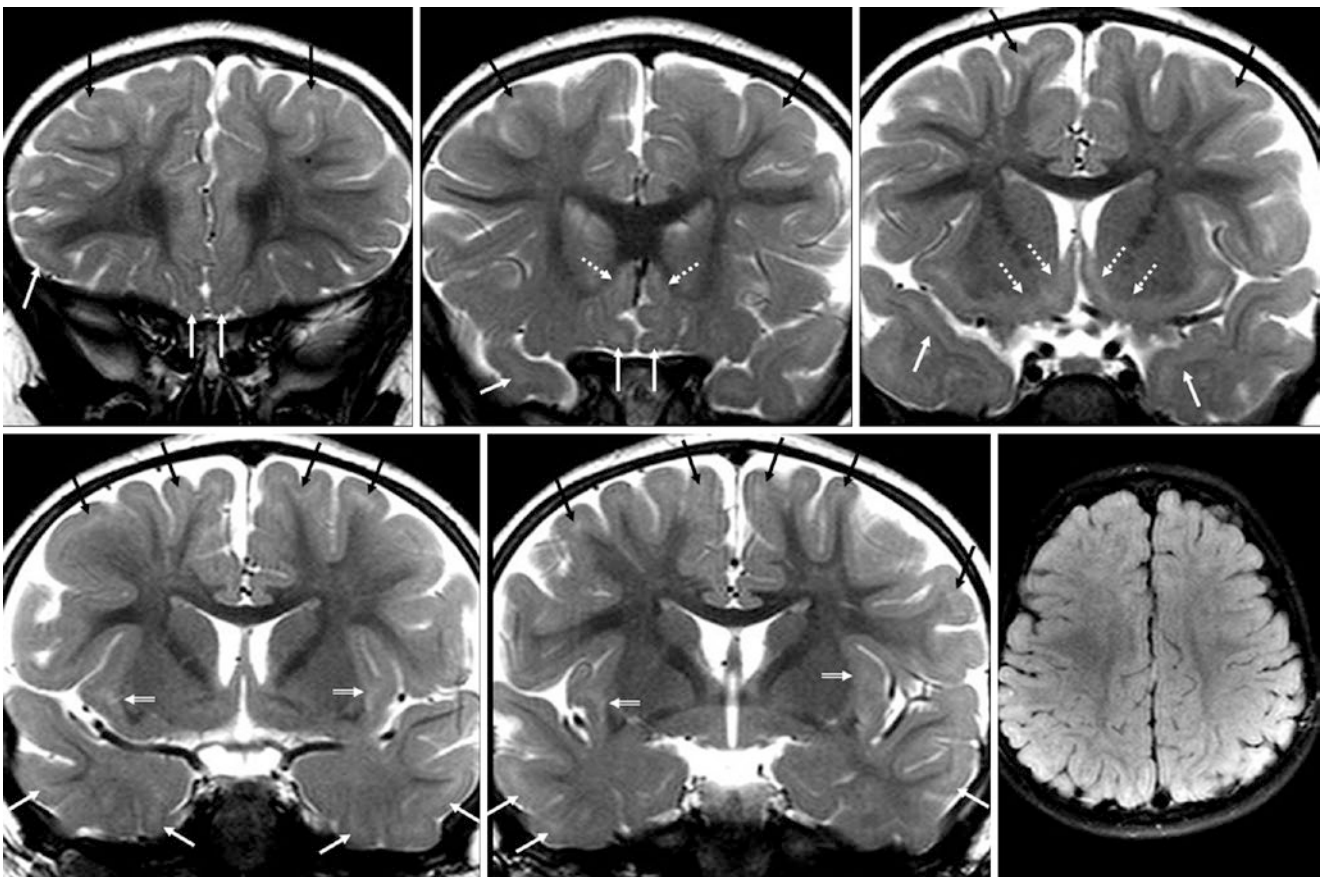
A 21.5-month-old with symptoms of rage and obesity had a normal 3T MRI. On coronal SE T2WI (*top row and bottom left and middle*), note tiny residual patchy SCWM hyperintensity (*thin arrows*) within the anterior-inferior frontal WM, anterior superior frontal gyri, and ATWM. Also, note bright signal from immaturity within the SIWM
